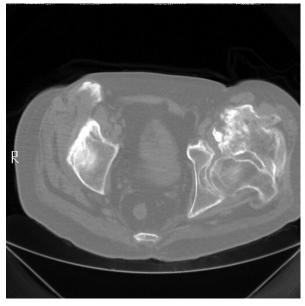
(a) Radiograph showing severe heterotopic ossification involving bilateral hips. (b) Computed tomography scan shows large mass of bone anterior to the left acetabulum. (c) Heterotopic ossification can indirectly cause pressure ulcers through restriction of joint range of motion, which results in pelvic obliquity when seated. In this patient with severely limited left hip flexion, a seating interface pressure transducer map placed between the patient and wheelchair cushion demonstrates increased pressure (yellow and red colors) posterior to the right greater trochanter.
